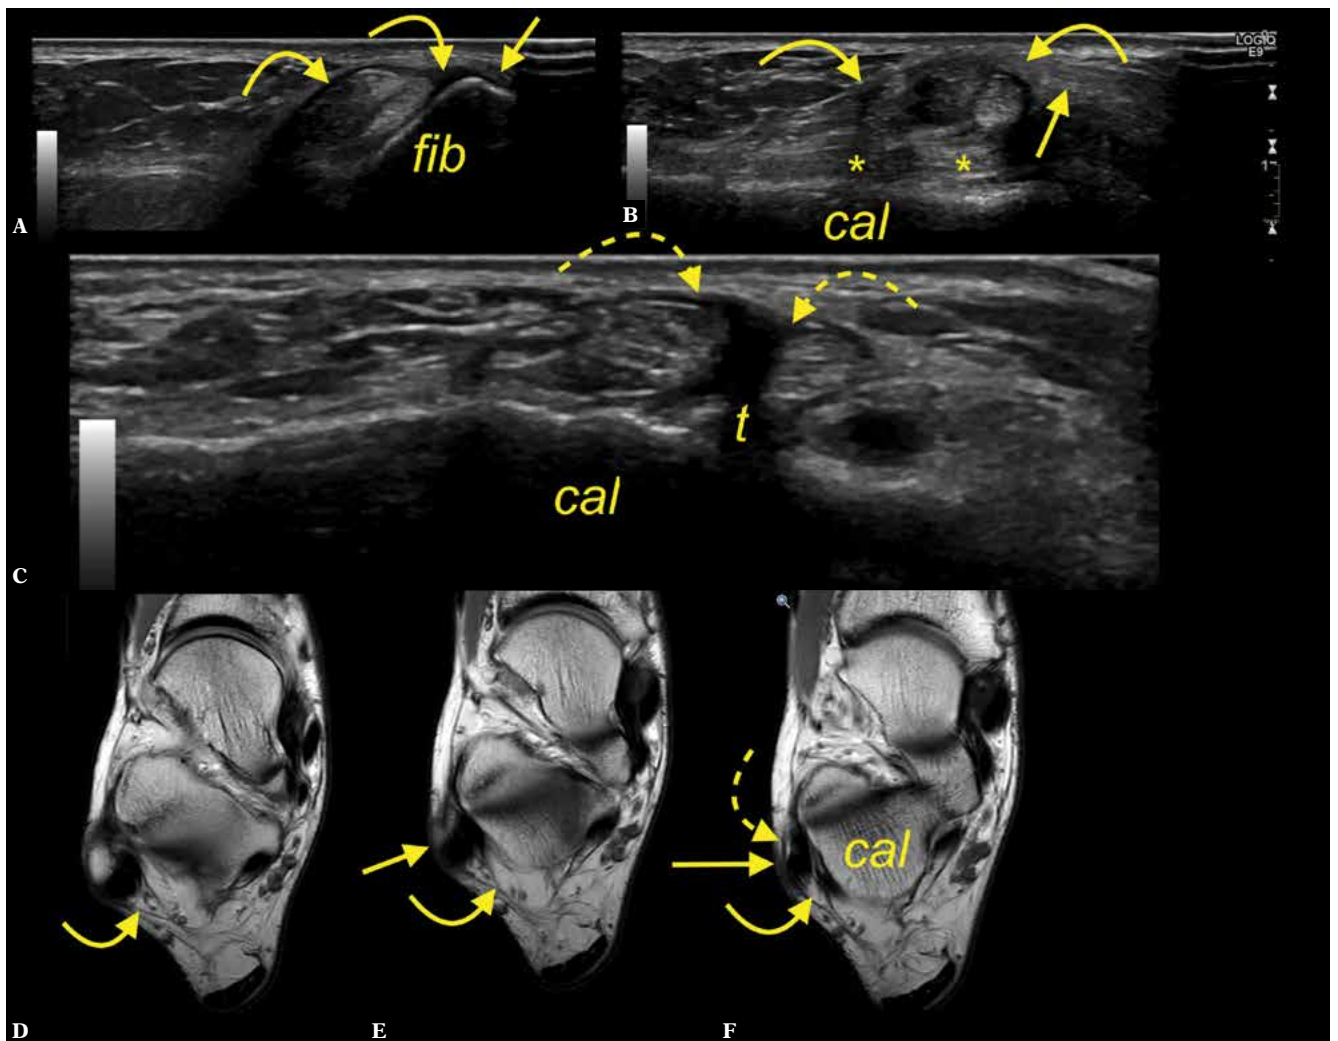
A 28-year-old patient with a clinical suspicion of an intraarticular free body in the ankle joint. A. transverse section at the level of the lateral malleolus (fib – fibula), SPR – curved arrow, connection to the PTS (straight arrow). B. oblique section along the calcaneofibular ligament (asterisk). C. coronal section at the level of the peroneal tubercle (t), PTS – dashed arrow, calcaneus – cal. D, E, F. MRI proton density-weighted axial sections
